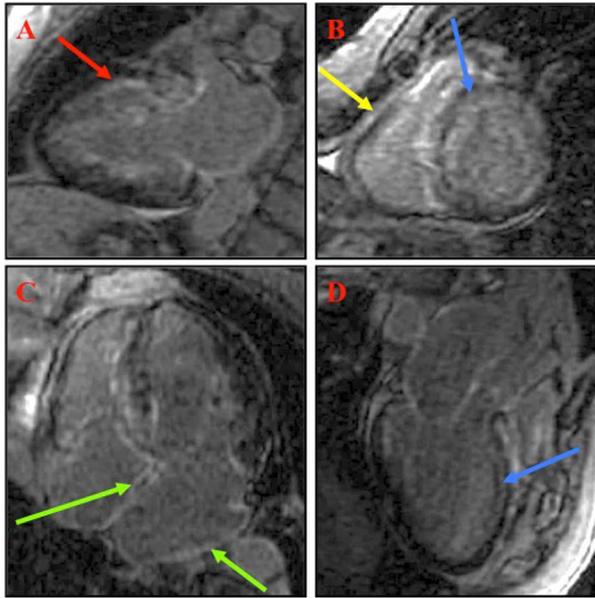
Cardiac magnetic resonance imaging. Cardiac MRI performed for viability assessment revealed subendocardial infarct in the left anterior descending (LAD) artery distribution (red arrow), diffuse right ventricular myocardial (yellow arrow), patchy left ventricular myocardial (blue arrows), and biatrial (green arrows) delayed gadolinium enhancement.
